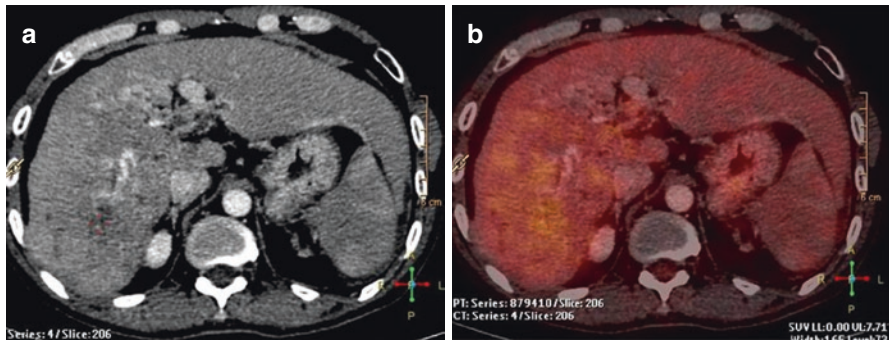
12 × 9 × 9 cm mass in the right lobe of the liver with thrombosis of the right and main portal vein as seen on the transaxial CECT images (a). The correlative transaxial images of the FDG PET/CT study show no significant FDG uptake in the liver lesion (b) suggestive of a tumor with good biology
